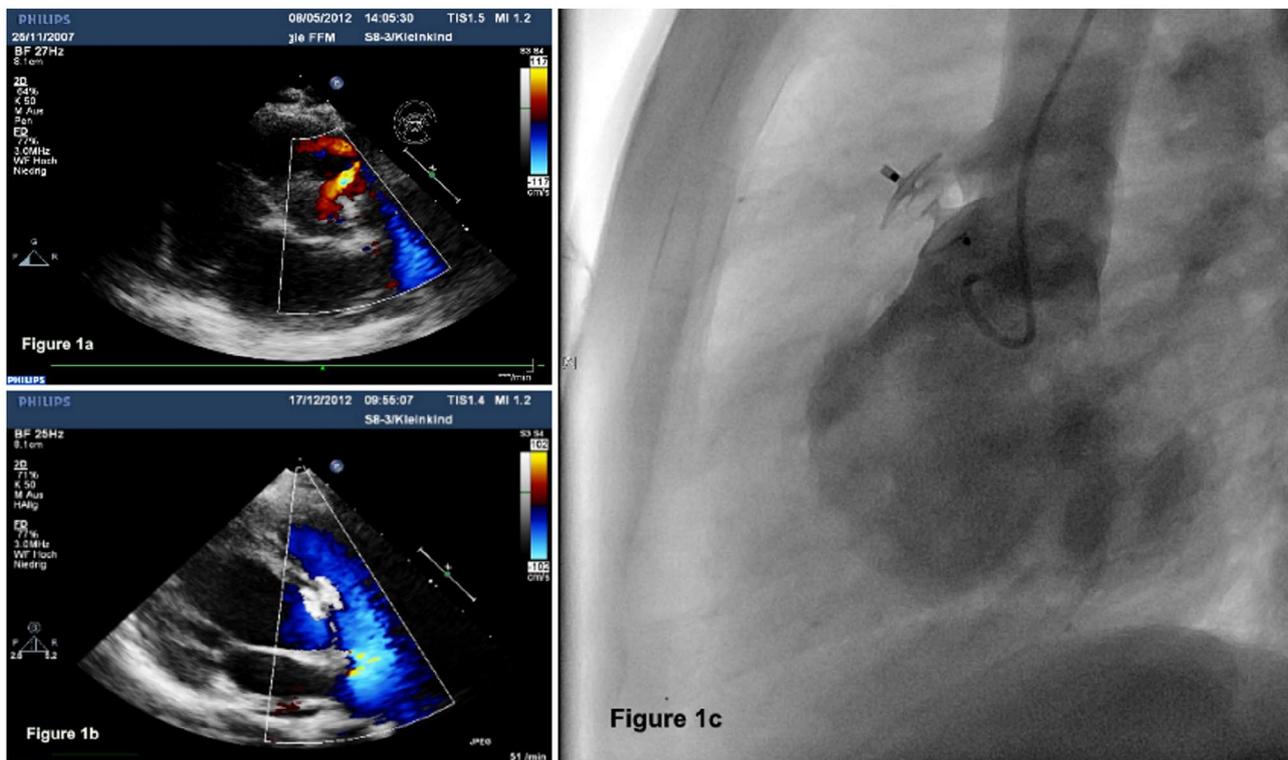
Shows an infundibular VSD before and after device closure in a 5-year-old boy (Patient 6) by echocardiography and cine-angiography. A, The colored jet flow from the left ventricle to the subpulmonary region, looking like an almost doubly committed VSD position. B, The ADOII (5 \times 4 mm) is depicted with laminar subpulmonary flow without residual shunt across the device closed defect. C, The released device position during the final left ventricular angiography
